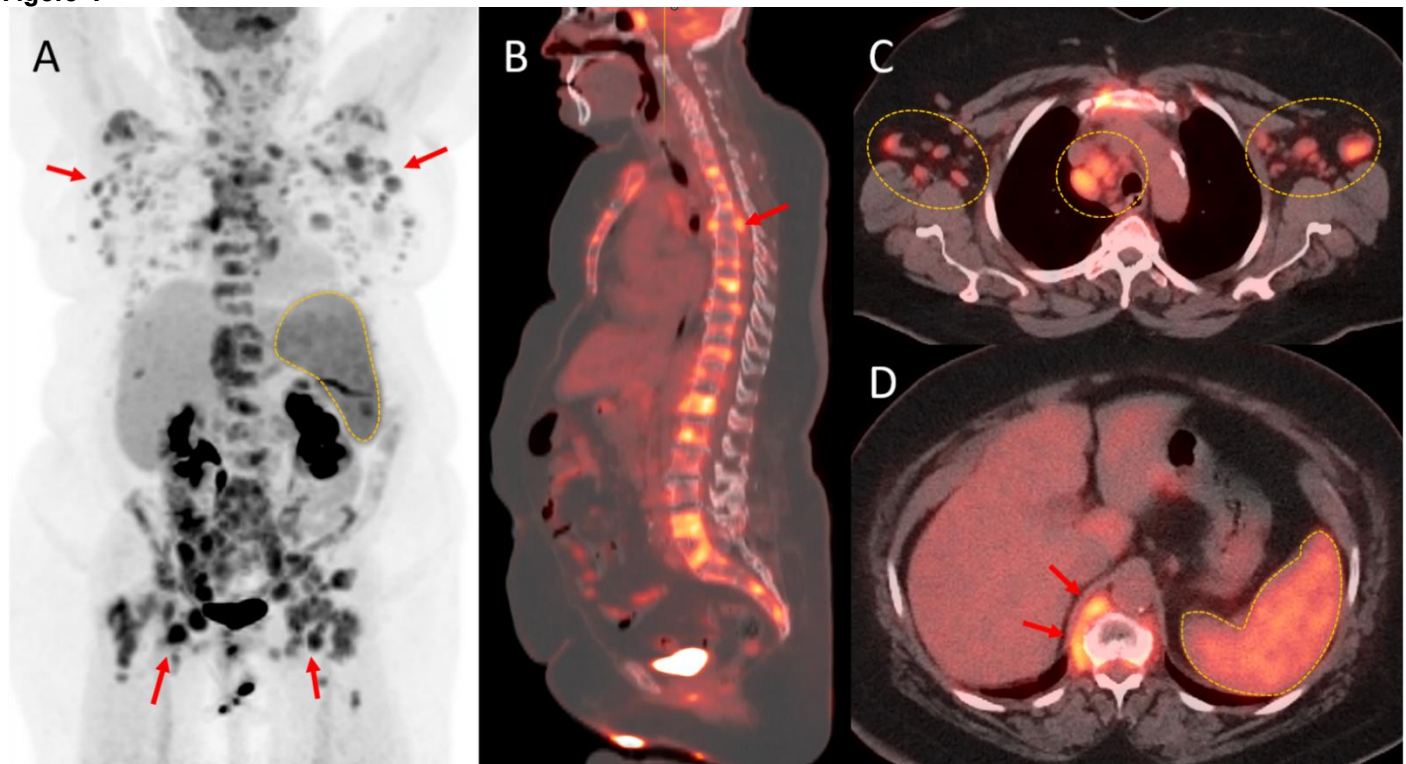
A) Maximum intensity projection of the whole body ^{18}F -FDG PET shows multi-station hypermetabolic lymphadenopathy including the axillary and inguinofemoral region (arrows), and hypermetabolic spleen (dotted line), with uptake level well above the reference liver, consistent with lymphoma. B) Sagittal PET/CT shows multiple hypermetabolic lesions in the spine and skull base consistent with osseous and marrow involvement. Focal activity apparently within the spinal canal (arrow) was concerning for epidural disease and was confirmed as subtle enhancement on subsequent MRI (not shown). C-D) Axial PET/CT demonstrates the axillary and mediastinal hypermetabolic lymphadenopathy (dotted ellipse), paravertebral disease adjacent to lower thoracic vertebrae (arrows) and hypermetabolic spleen (dotted ROI).
